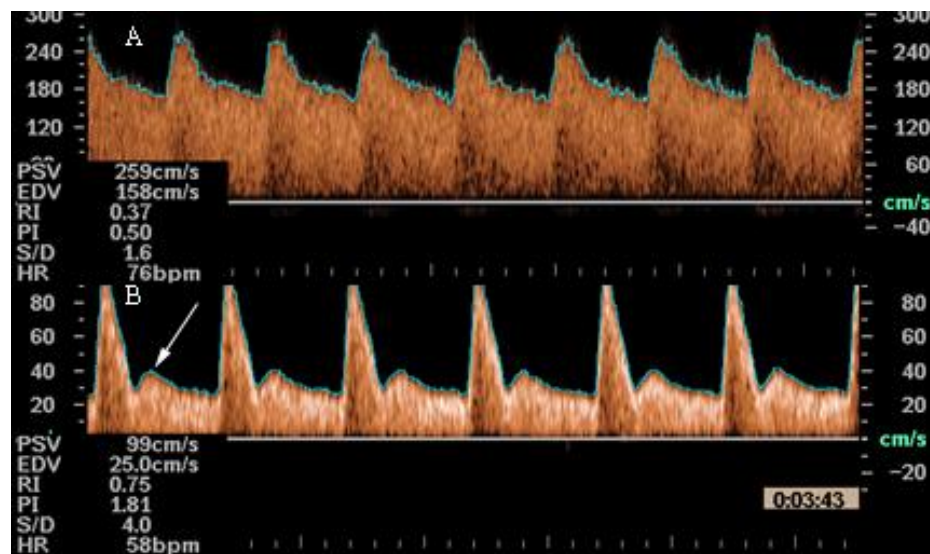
Blood velocity signals recorded from uterine arteries using spectral Doppler ultrasound. A) Uterine artery velocity waveform in an uncomplicated pregnancy. The high proportion of diastolic velocities indicates low resistance to flow in uteroplacental circulation. B) Doppler velocimetry of uterine arteries in a pregnancy with preeclampsia and intrauterine restriction. The proportion of diastolic velocities is decreased and in the early diastole there is a “notch” (arrow), indicating increased resistance.
